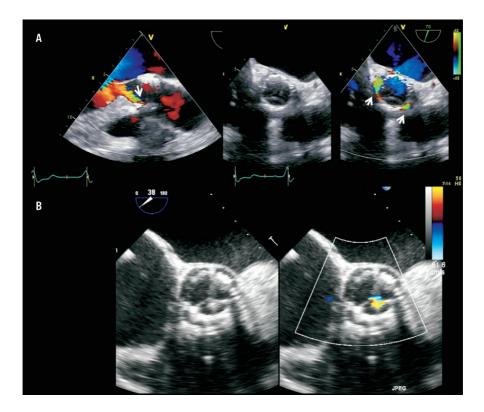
Panel A shows the long-axis view of the aortic root on conventional 2-D transoesophageal echocardiography of a patient who underwent transcatheter aortic valve implantation with a balloon-expandable valve. The arrow indicates the presence of mild paravalvular regurgitation at the level of the anterior part of the aortic annulus. The short-axis views show the exact location of the two jets of paravalvular regurgitation (arrows). Panel B shows a patient with transvalvular regurgitation, best noted on the short-axis view on transoesophageal echocardiography.
